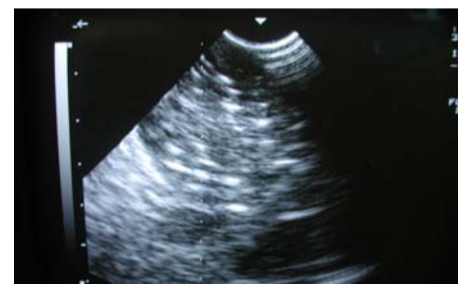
The seed distribution of ultrasound
